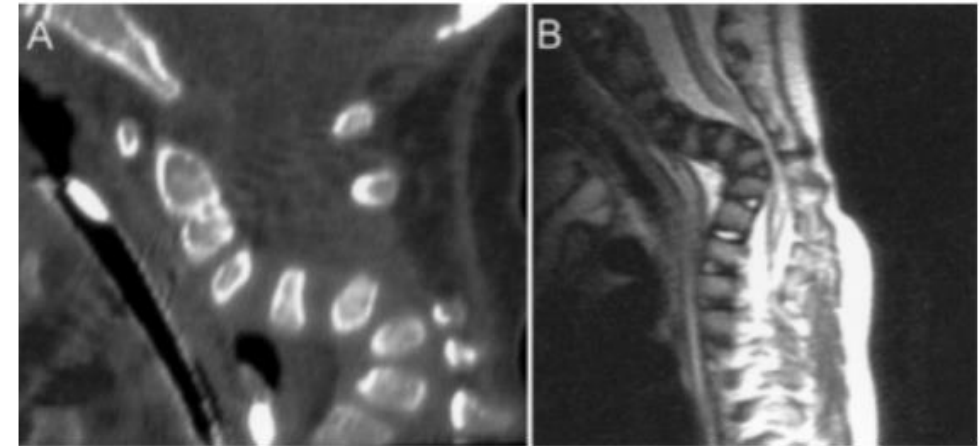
Case 1. A: Sagittal CT scan depicting the reverse swan-neck or buckling sagittal deformity and the hypoplastic pedicles. B: Sagittal T₂-weighted MR image showing the degree of spinal cord compression and high signal change within the cord.
